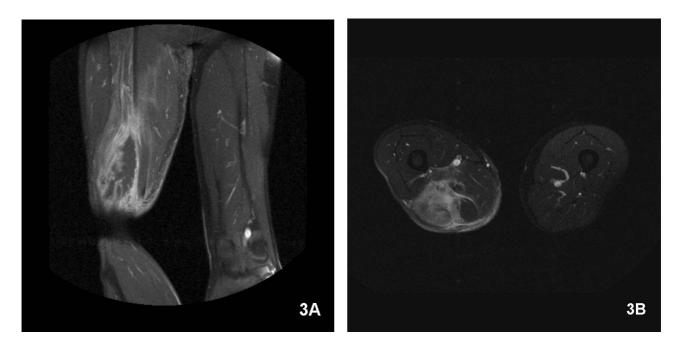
Post-contrast coronal T1-weighted fat saturated (FS) MRI reveals peripheral marginal contrast enhancement (A) and axial T2-weighted FS image reveals heterogenous hyperintensity (B) at the right biceps femoris muscle. Subcutaneous edema at posterior aspect of the entire right thigh is noted.
